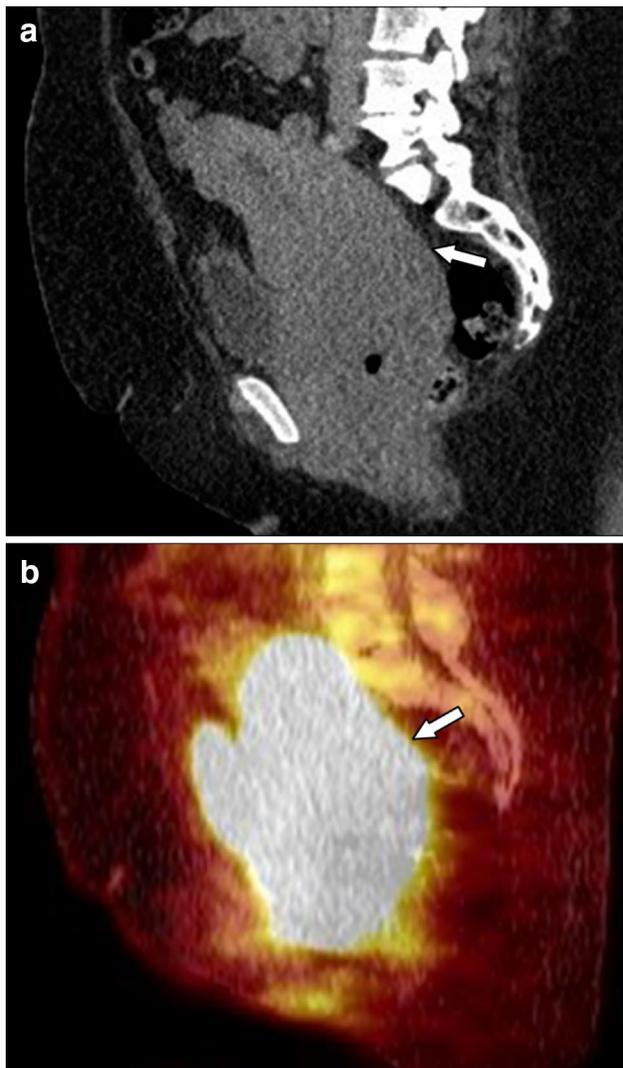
A 52-year-old patient with diffuse large B-cell lymphoma of the uterus, cervix, and vagina on contrast-enhanced CT (a, arrow) and increased uptake on PET/CT scan (b, arrow)
